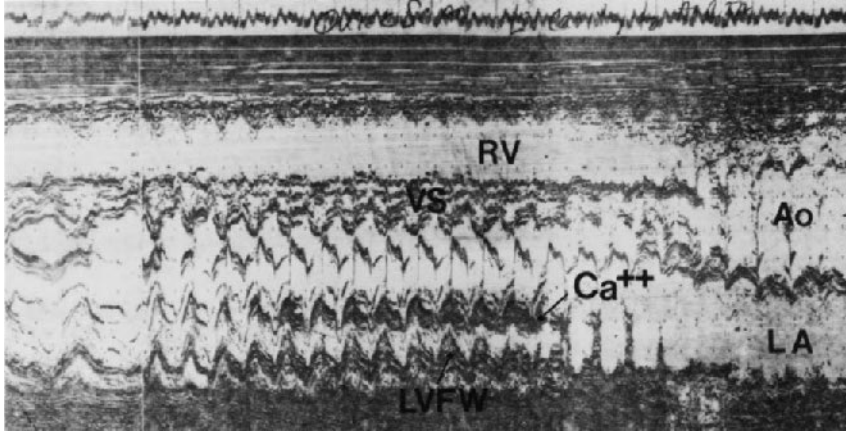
M-mode echocardiogram obtained 10 months before death (SH #80-18). The ascending aorta (Ao) has a larger diameter than the left atrium (LA). The left ventricular (LV) cavity is small. Calcium is present in the mitral annular region. (I thank Dr. Robert Montgomery, Bethesda, Maryland, for allowing me to show this echocardiogram from his patient.)
